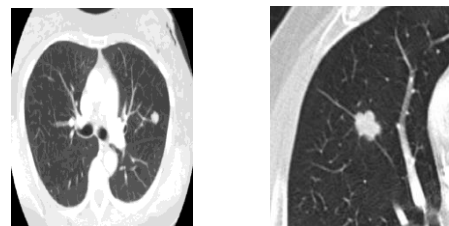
lung nodule CT scan images
